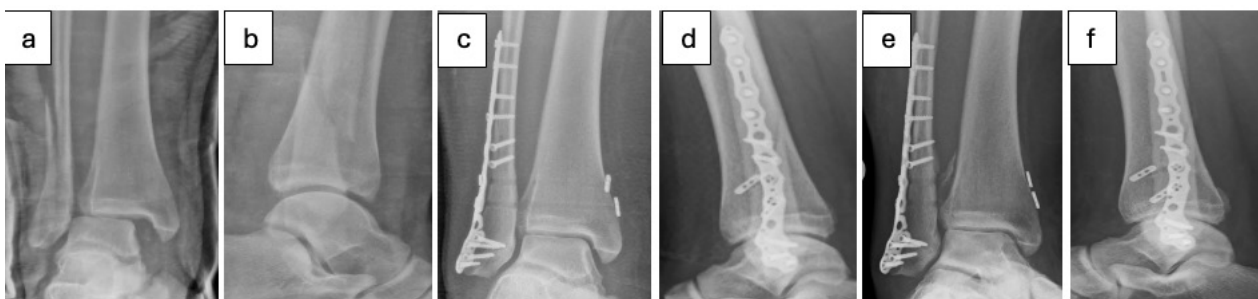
X-ray images of a patient with the bimalleolar ankle fractures associated with syndesmosis injury fixed with a Double Tightrope: Preoperative (a, b), Early Postoperative (c, d), and Final Follow-up (e, f).
